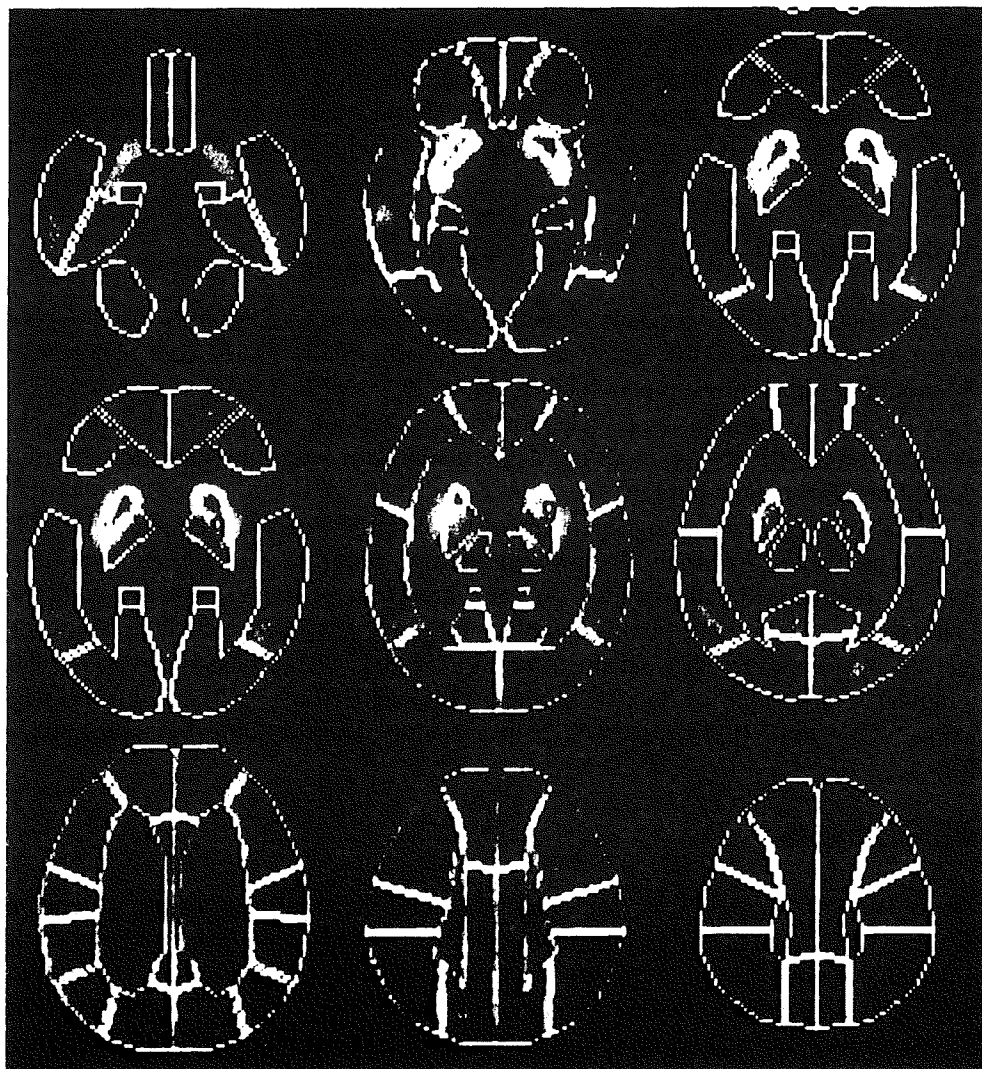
Positron emission computed tomography, (PET) images using ^{11}C -N-methylspiperone in a healthy volunteer subject with ROI delineation (*white*) by 3DSRT. Number (*red*) shows each region of the brain. 1: Callosomarginal, 2: Precentral, 3: Central, 4: Parietal, 5: Angular, 6: Temporal, 7: Occipital, 8: Pericallosal, 9: Lenticular Nucleus, 10: Thalamus, 11: Hippocampus.
